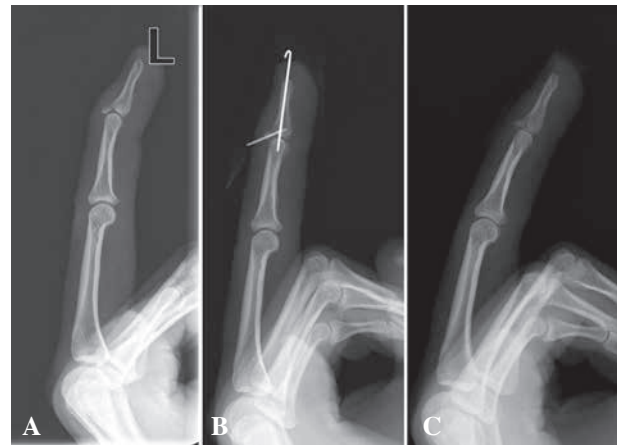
A 25 year-old-male with a mallet fracture of the left middle finger. (A) Preoperative X-ray of the type IB mallet fracture. (B) The X-ray immediately after surgery shows reduction state without displacement. (C) The X-ray 3 weeks after surgery shows well-maintained reduction after removal of the needle and Kirschner wire.
